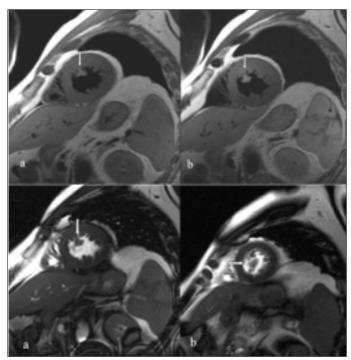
In T1 weighted (a) and T2 weighted (b) cardiac magnetic resonance imaging study, short axis views show hyperintense mass image derived from anterior myocardial wall in the left ventricular cavity (white arrow, upper images). Additionally, T2W study reveals an old infarction in the spleen (black arrow, upper images). In true FISP short axis sequences, pedunculated mass image derived from anterior and inferior wall is seen (arrow, lower left and lower right images)
